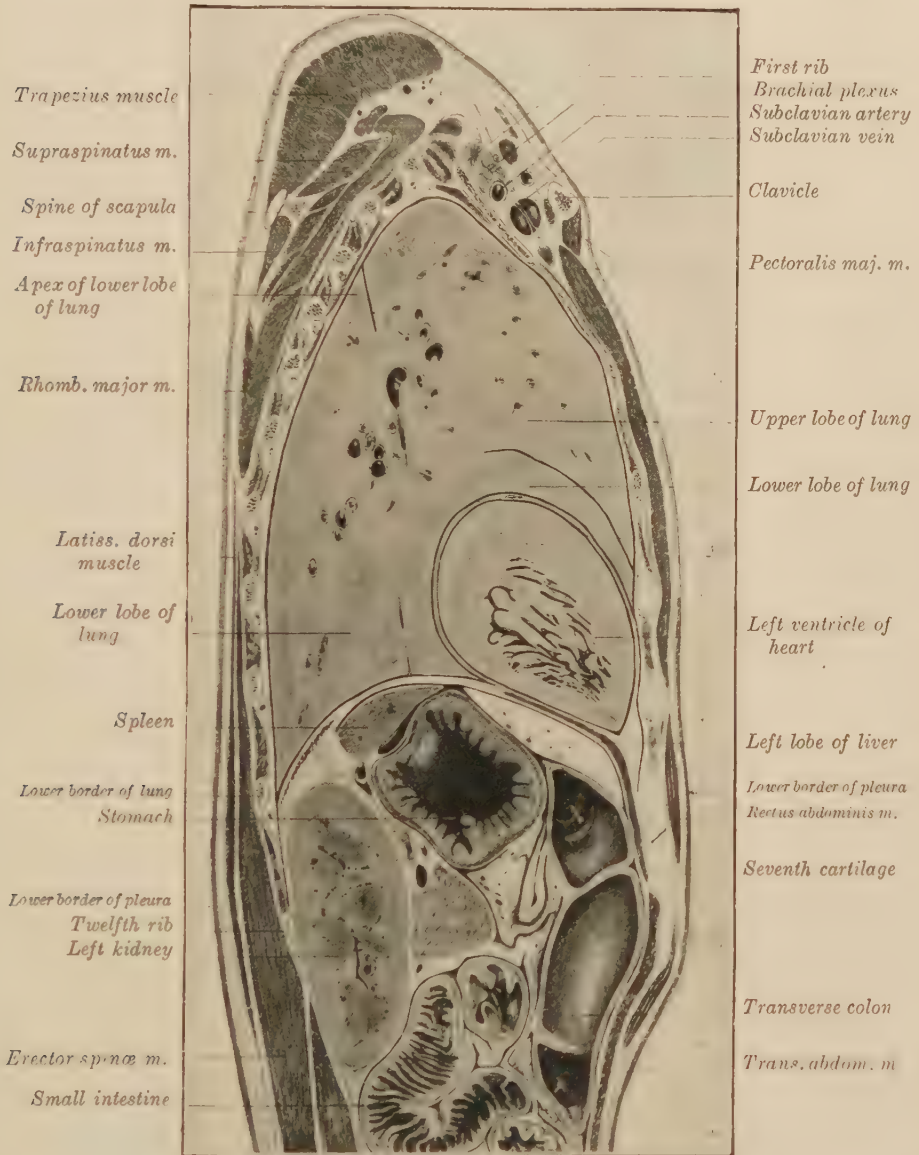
SAGITTAL SECTION OF THE TRUNK OF A MAN AGED FORTY YEARS, MADE ABOUT 6 CM. TO THE LEFT OF THE MEDIAN PLANE, VIEWED FROM THE MEDIAN ASPECT. One-third natural size. (J. S. Dickey.)
